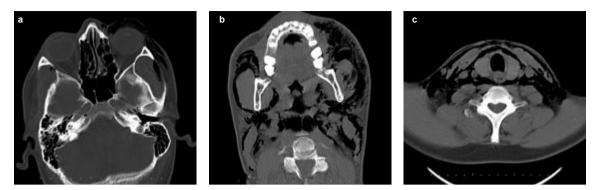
a-c. Computed tomography revealed diffuse cervicofacial emphysema. There are air bubbles in the left orbital cavity (a). The presence of air density in the left masseter muscle (b); Emphysema within the fascial layers of the neck (c)
